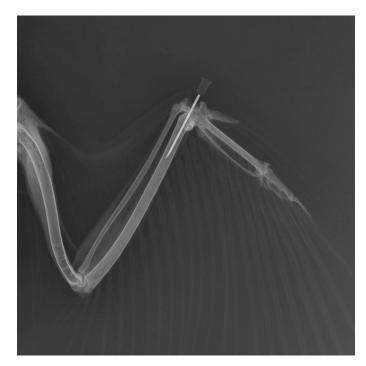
Intraosseous perfusion (radiographic image)
